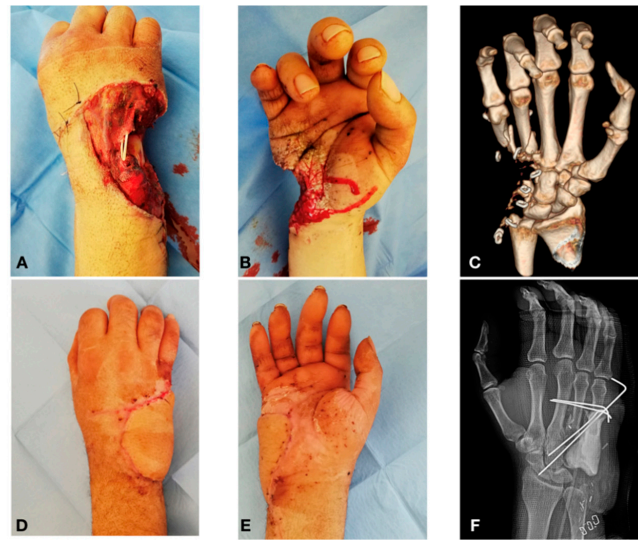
(A) Hand wound: dorsal view with extensor tendon exposure; (B) Hand wound: volar view; (C) TC 3D bone lesion; (D) 2 month post-operative, dorsal view; (E) 2 month post-operative, volar view; (F) X-ray post-operative control.
